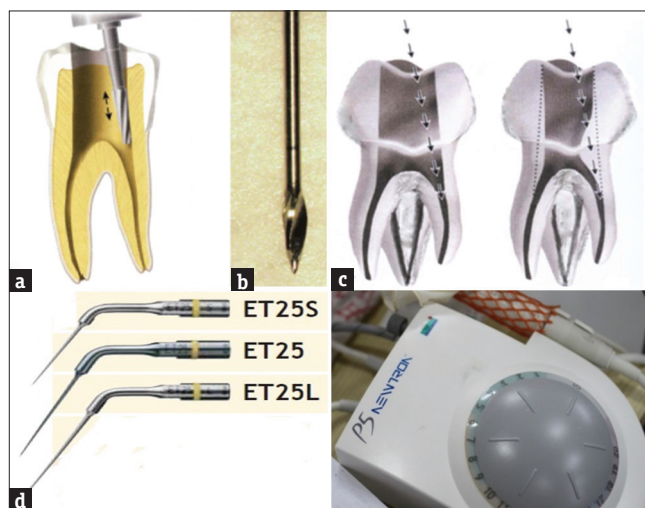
(a) A safety-end fissure bur was used to access the crown (arrows) of the mandibular molar. (b and c) a Gates-Glidden drill was used to achieve straight-line access in the coronal third of the molar (arrows). (d) The EndoSuccess kit of ultrasonic tips features novel titanium–niobium instruments consisting of ET25 S, ET25, and ET 25 L tips and a piezoelectric ultrasonic generator (Suprasson Newtron P5)
